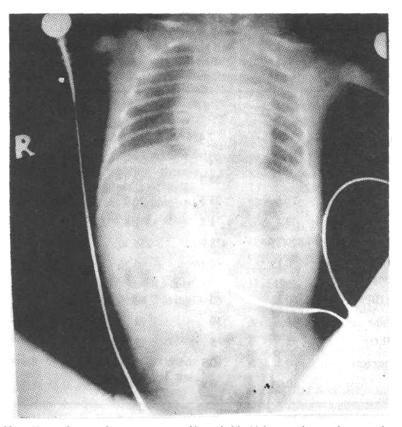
Chest X-ray showing better aeration of lung fields 12 hours after surfactant administration.
